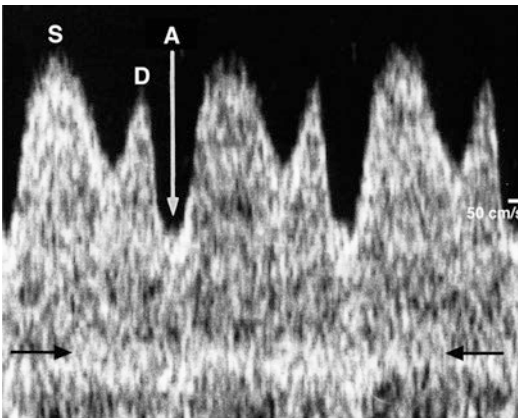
Doppler recording of the blood velocity at the isthmus of the ductus venosus at 33 weeks of gestation. Typically, there is high velocity during the entire cardiac cycle with a peak during ventricular systole (*S*), another peak during passive diastolic filling (*D*), and a deflection (white arrow) during atrial contraction (*A*). The velocity of the interfering umbilical vein is faintly seen between the black arrows, as the sample volume has covered both the isthmus and a portion of the connected umbilical vein
